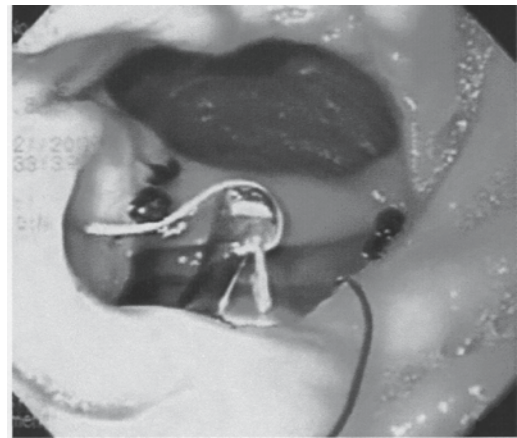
Endoscopic view from the gastroesophageal junction demonstrates the EndoStitch (Autosuture, Norwalk, CT) suturing device being used to perform gastro-gastric fistula closure.
